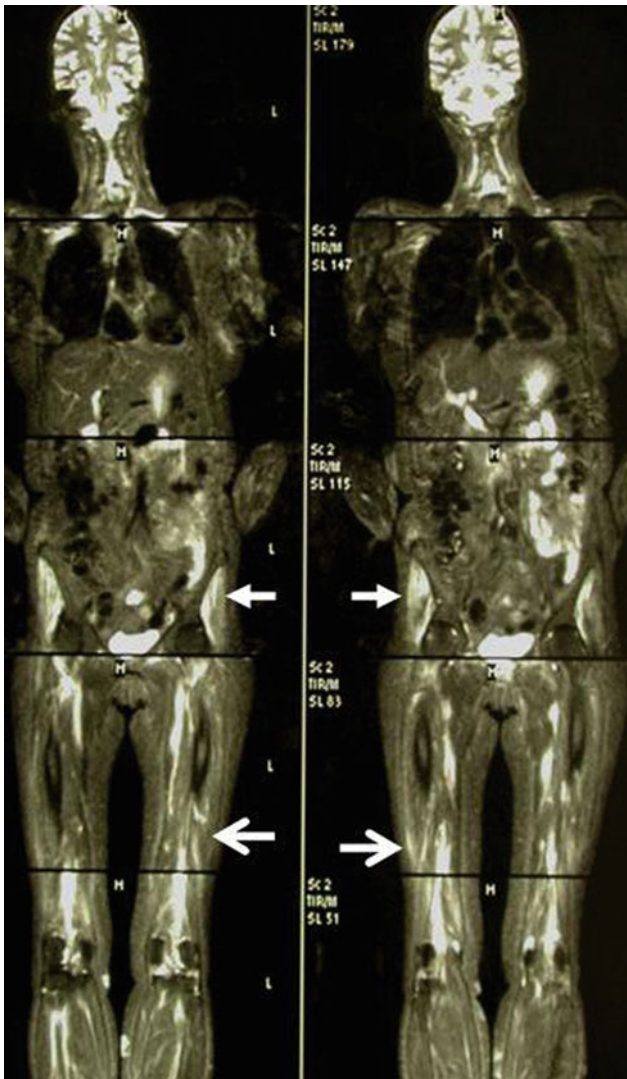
Whole-body STIR MRI showing diffuse muscle edema involving the pelvic girdle muscles (*solid arrowhead*) and proximal thigh musculature (*pointed arrowhead*) typical of polymyositis. Note the characteristic lack of subcutaneous edema
